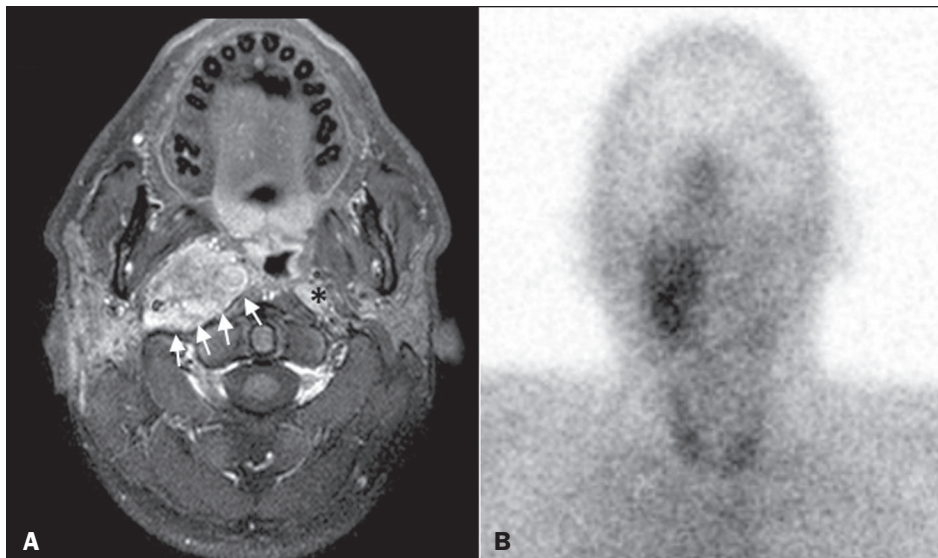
MRI and SRS images of patient A1, who received a confirmed diagnosis of metastatic paraganglioma. Axial gadolinium-enhanced fat-suppressed T1W image (A) shows a hypervascular lesion in the right parapharyngeal space (arrows) and a left retropharyngeal lymph node (asterisk). SRS (B) missed the metastatic lymph node.
